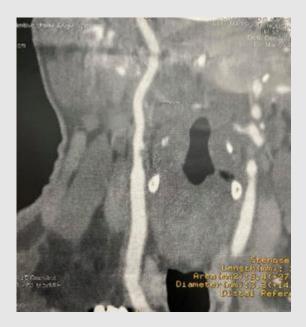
CT angiography showing the free-floating thrombus in the right internal carotid artery.
